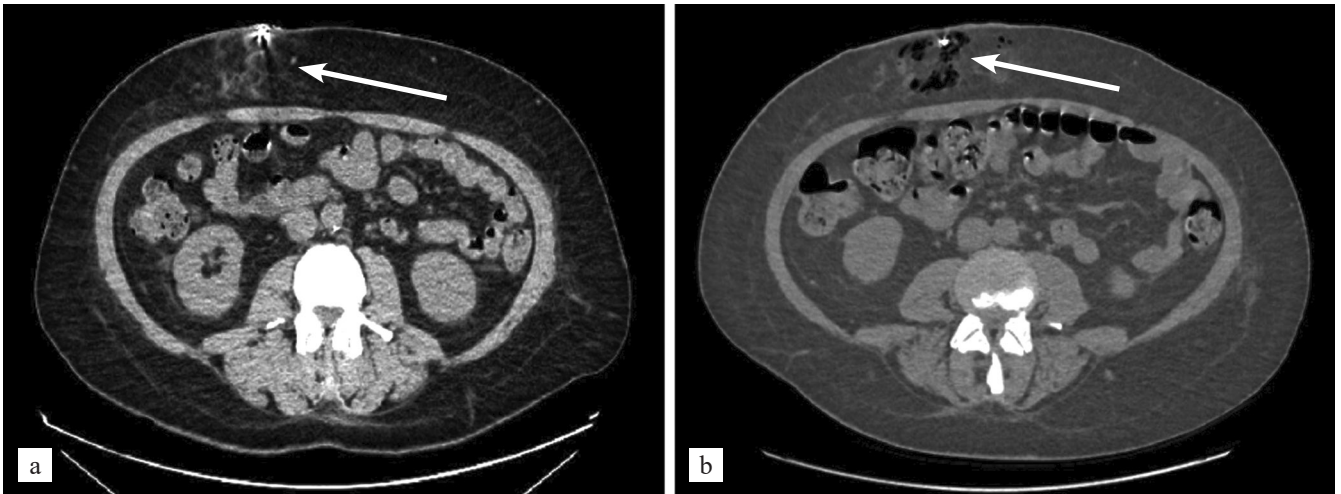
CT image showing the spread of infection in the subcutaneous adipose tissue along the driveline of a long-term MCS system. (a) The arrow indicates an area of infiltration in the subcutaneous adipose tissue surrounding the driveline. (b) The arrow indicates gas accumulation within the subcutaneous adipose tissue around the driveline
